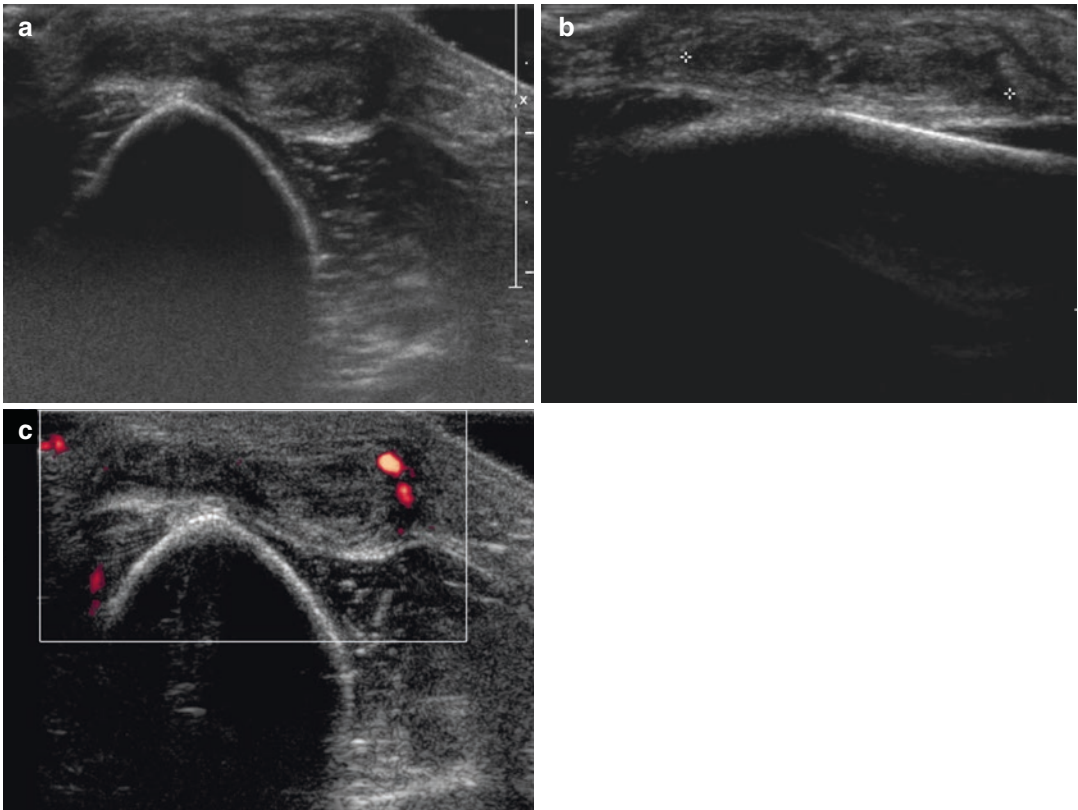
Rheumatoid nodule. Transverse (a) and longitudinal (b) US images reveal a heterogeneous, predominantly hypoechoic mass over the extensor surface of the elbow. Color Doppler study (c) shows limited peripheral vascularity
